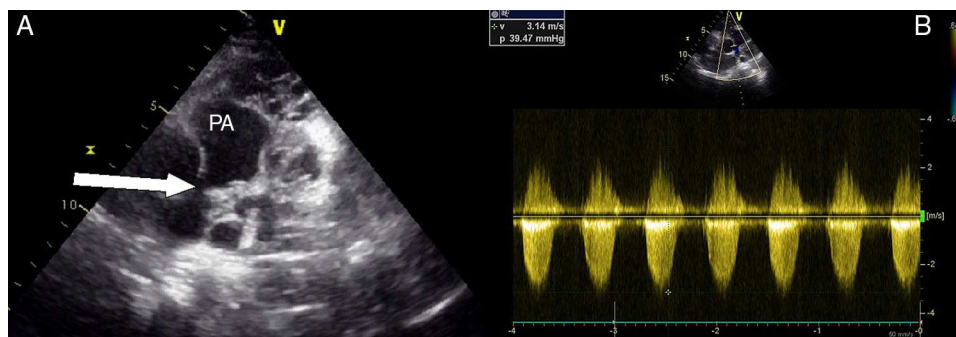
Transthoracic echocardiographic views showing (A) multiple cystic mass compressing the pulmonary artery and (B) continuous wave Doppler of the pulmonary artery with maximum gradient of 40 mmHg. PA: pulmonary artery.
